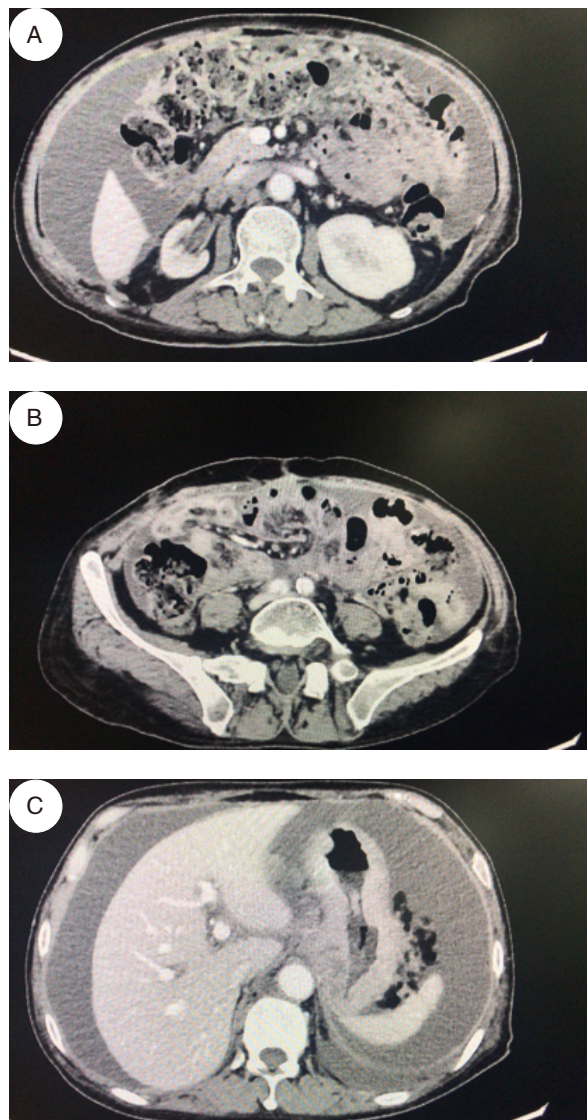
The patient's abdominal CT
